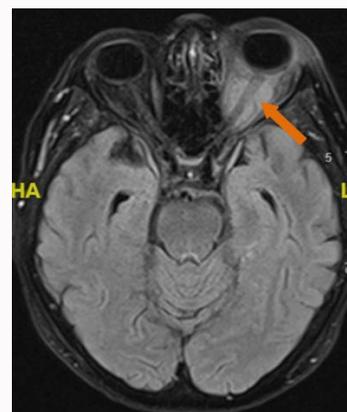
Intracranial extension of mass around the optic nerve in the left orbit (brain CT).
